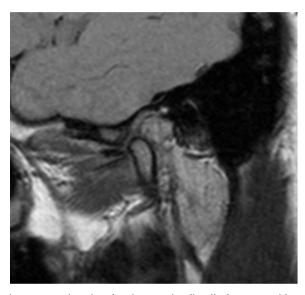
Magnetic resonance imaging showing anterior disc displacement without reduction and even contours of the condylar head.
